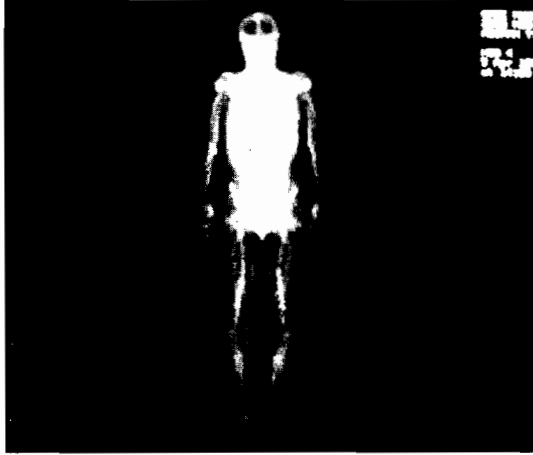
Anterior whole body scintigraphy with Tc-99m HIG in a clinically non-active RA patient without synovitis of peripheral joints.
